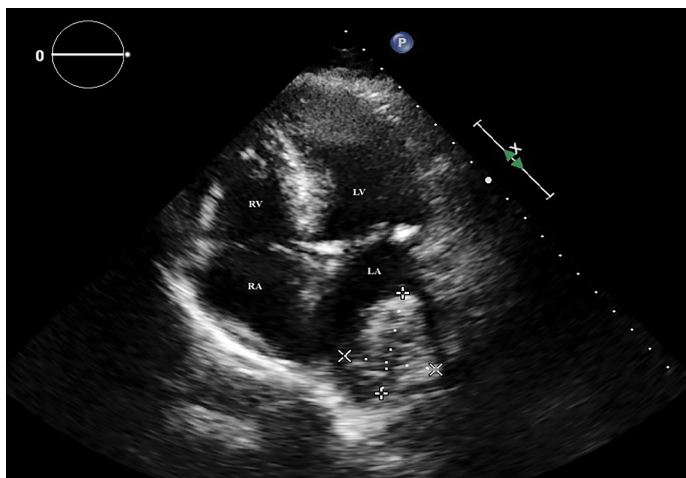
The apical four-chamber view demonstrating a heterogeneous mass within the left atrium
